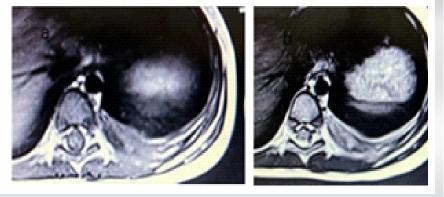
The magnetic resonance examination revealed that, the lesion was hypointence in T1 (a) and hyperintence in T2 (b) weighted MRI, with thin internal septations and suggestive of rib osteomyelitis.
